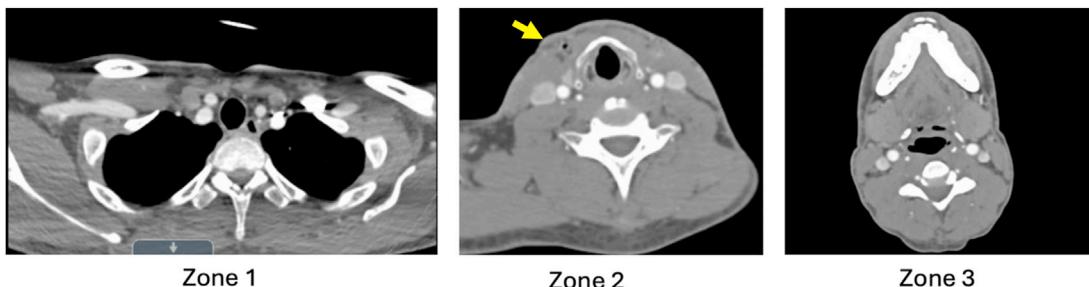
Neck zones on CTA: The axial computed tomographic angiography (CTA) images correspond to zone 1, zone 2, and zone 3 from a patient with a right zone 2 neck stab wound (notice the small volume of emphysema at the level of the thyroid cartilage: yellow arrow, but no vascular or aerodigestive injury noted).
